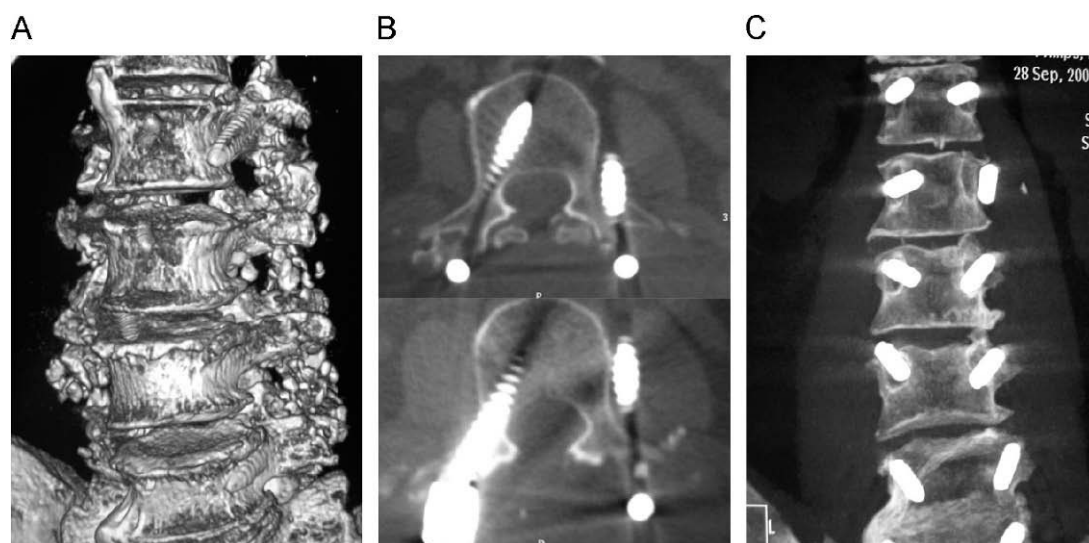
A) Anterior view of a 3D CT-reconstruction showing the extrapedicular course of the screw at the second left lumbar vertebra. B) Axial slices. C) Coronal slice.
